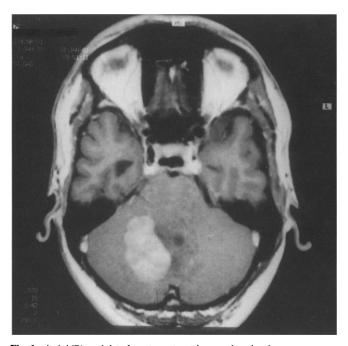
Axial T1-weighted post-contrast image showing heterogeneous mass in the right cerebellar hemisphere. The solid component is nodular and homogeneously enhancing
